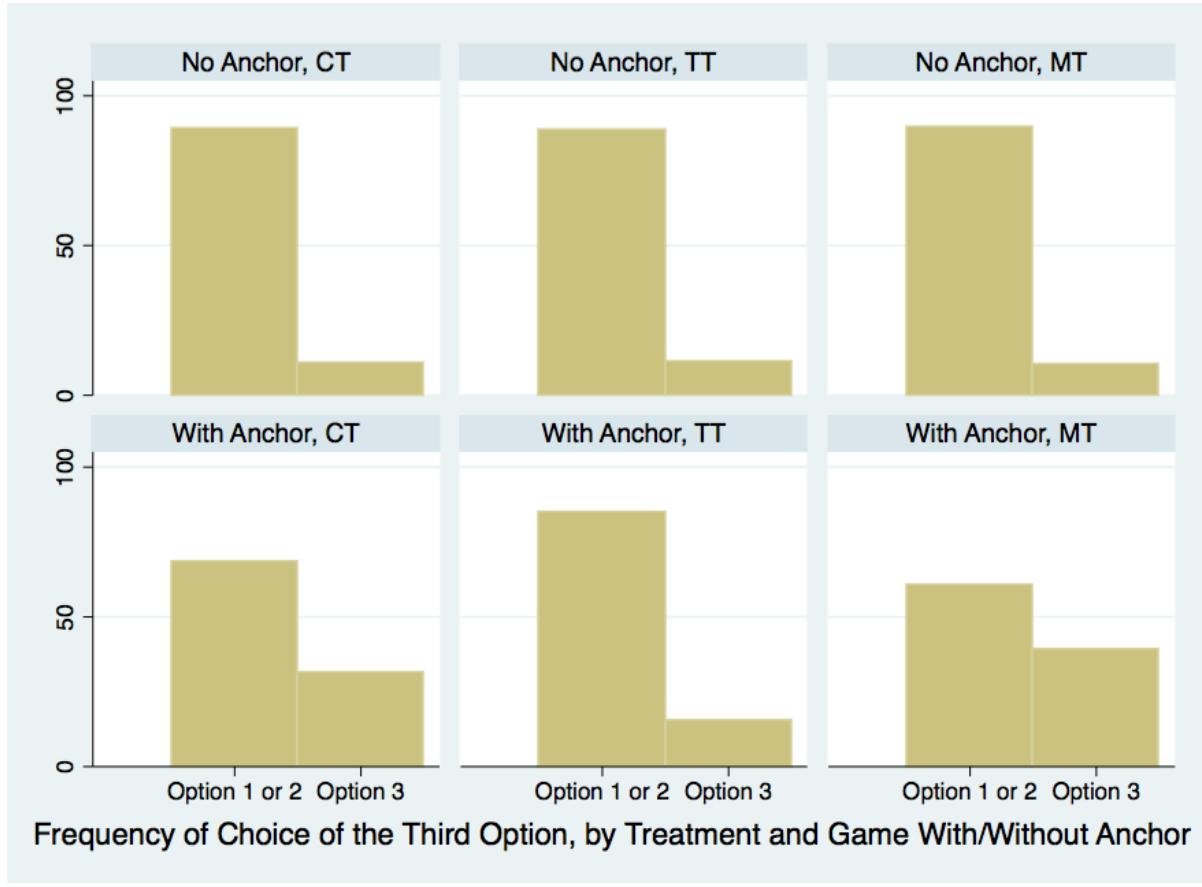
Distribution of choice of third option by treatment (CT = Control Treatment, TT = Time pressure Treatment, MT = Motivation Treatment) and by the presence/absence of the anchor.
